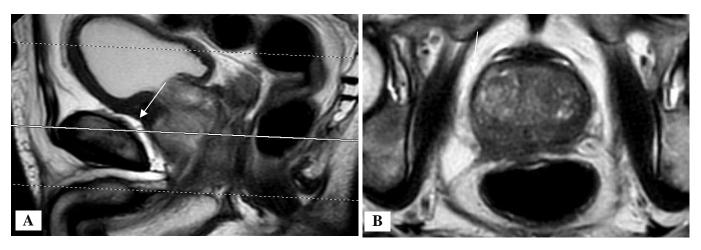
Sagittal and axial MRI T2 weighted images pre-radiation in a case of metastatic castrate resistant prostate cancer.
